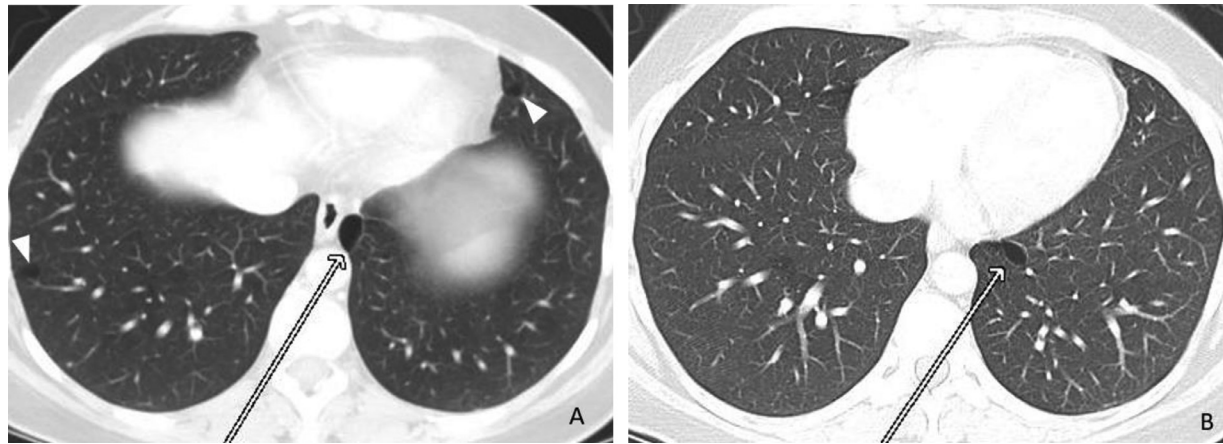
Axial CT of the lower chest showing small subpleural blebs at both lung bases (white arrowheads in A), with the largest bleb (white arrow) in the left medial lung. No pneumothorax is seen.
